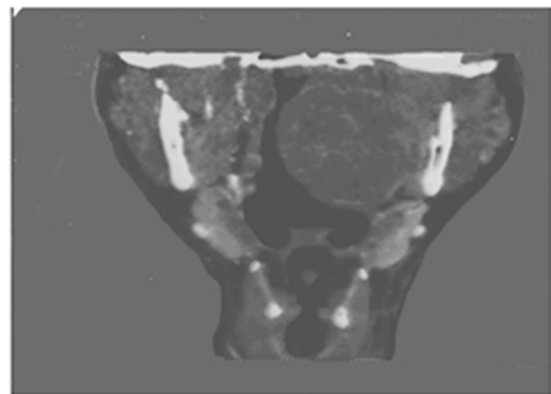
CT coronal section of the lesion
